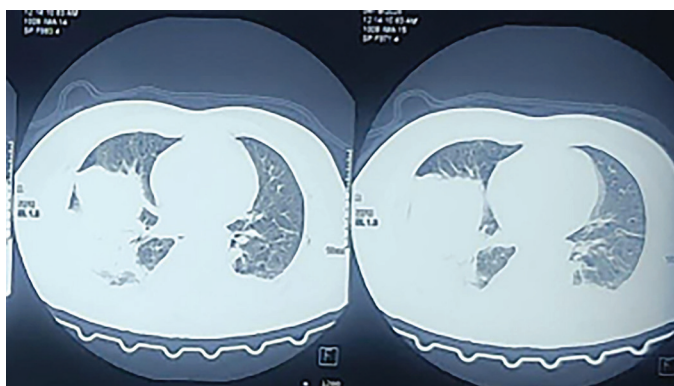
Computed tomography chest showing right sided hemothorax
